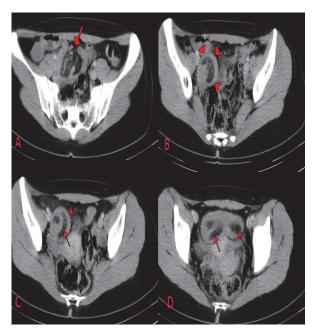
Contrast-enhanced abdominal computed tomography scans demonstrate (A) typical intussusception with a lead point (arrow), (B, C) target sign and associated bowel wall thickening (arrow heads) accompanied by entrapped perienteric fatty tissue (arrow), (D) intraluminal elongated fatty mass entrapped in perienteric fatty tissue (arrows).
